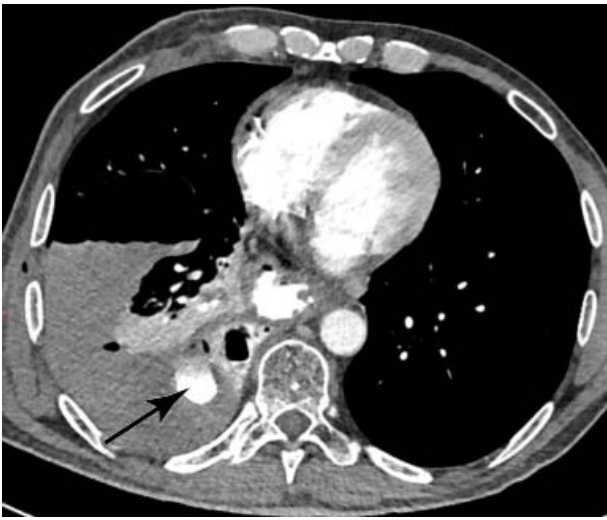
CT imaging with oral iodine-based contrast agent: leakage through a defect to the right pleural cavity
